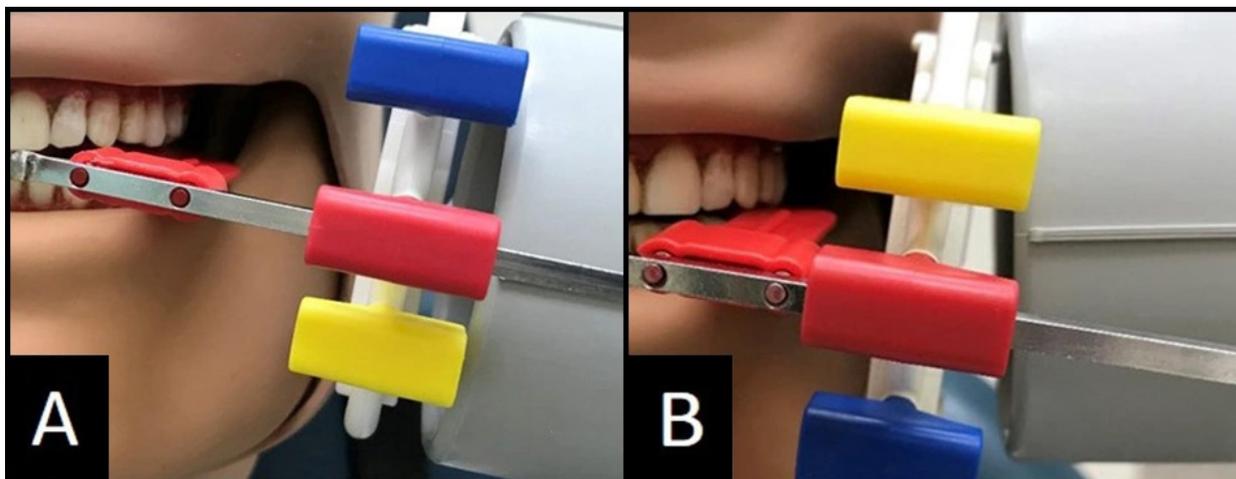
Bitewing not balanced.
